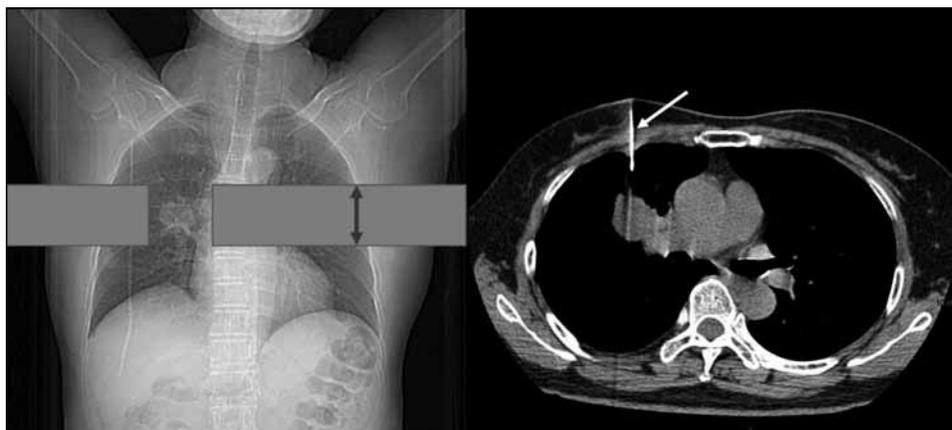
Scanogram and selected axial computed tomography slice during traditional multi-slice computed tomography-guided lung biopsy. This traditional method requires repeated scanning of the entire length of the lesion (height of the grey bar) after each needle adjustment (arrow) while advancing to the lesion.
